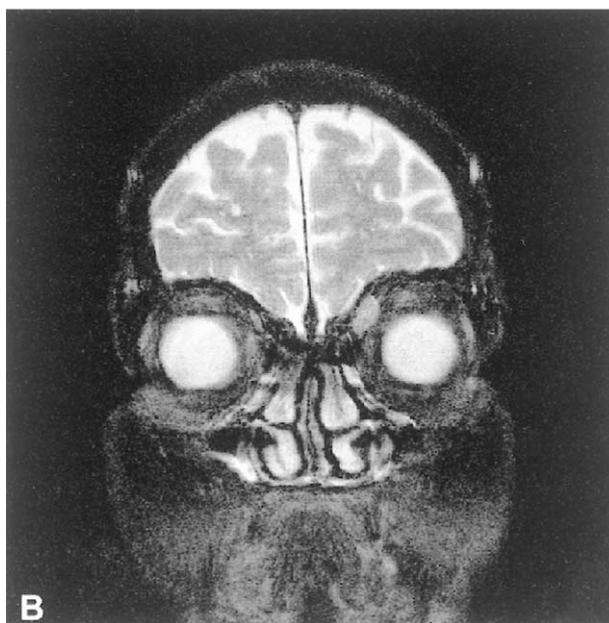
A:* Swelling in the mediosuperior corner of the left orbit in Case 4. *B:* Tumor demonstration on MRI scan with enhancement.
